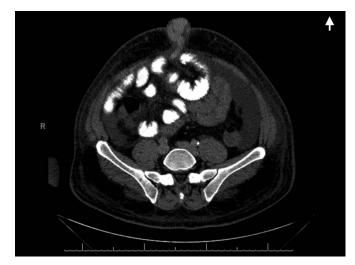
Axial computed tomography scan revealing a large recanalized umbilical vein protruding through an umbilical defect; no bowel or omentum was identified within the hernia sac.
